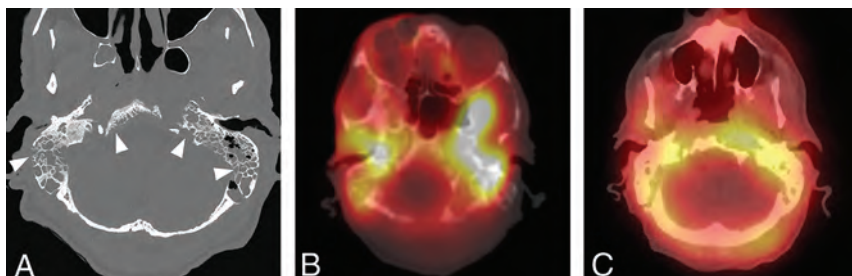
Extensive skull base osteomyelitis. A 70-year-old man with poorly controlled diabetes presented with symptoms of otomastoiditis with associated hearing loss, left facial nerve paralysis, and dysphagia. A culture of the left external auditory canal revealed *Pseudomonas* infection. The patient received aggressive treatment for several months, including IV vancomycin and piperacillin/tazobactam, but he ultimately died from meningitis and aspiration pneumonia. A, Axial CT demonstrates multiple focal areas of cortical dehiscence involving the temporal bones bilaterally as well as the clivus (arrowheads). The generalized erosion is compatible with diffuse osteomyelitis of the skull base. B, Axial fused Tc99m MDP bone scan SPECT image demonstrates significant accumulation of radiotracer in the skull base bilaterally, preferentially affecting the temporal bones. C, An axial fused gallium scan SPECT image shows bilateral accumulation of radiotracer in the temporal bones, with some extraosseous accumulation in the left preclival region.
